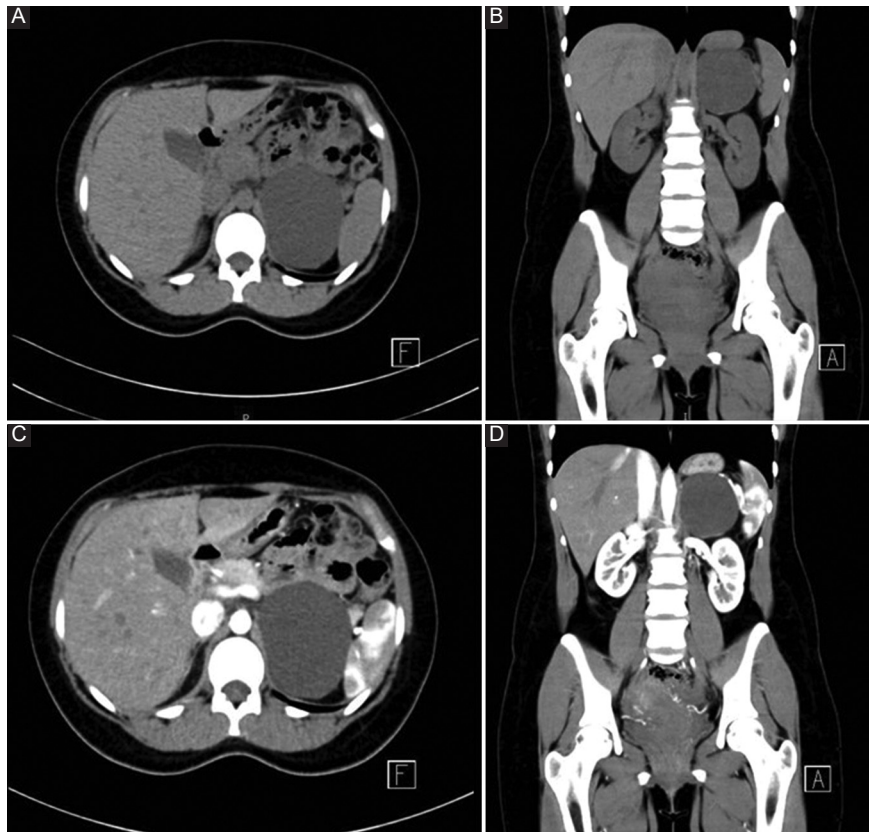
Computed tomography. A: Axial section without contrast. B: Coronal section without contrast. C: Axial section with intravenous iodinated contrast; no enhancement is observed. D: Coronal section with intravenous iodinated contrast; no enhancement is observed.
